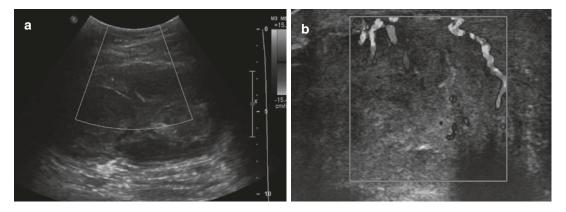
(a) and (b) transverse Doppler ultrasound of a solid thigh mass. The tumour in (a) and (b) demonstrates increased Doppler signal. Biopsy of the tumour in (a) confirmed a *UPS* and in (b) a *USCS*
